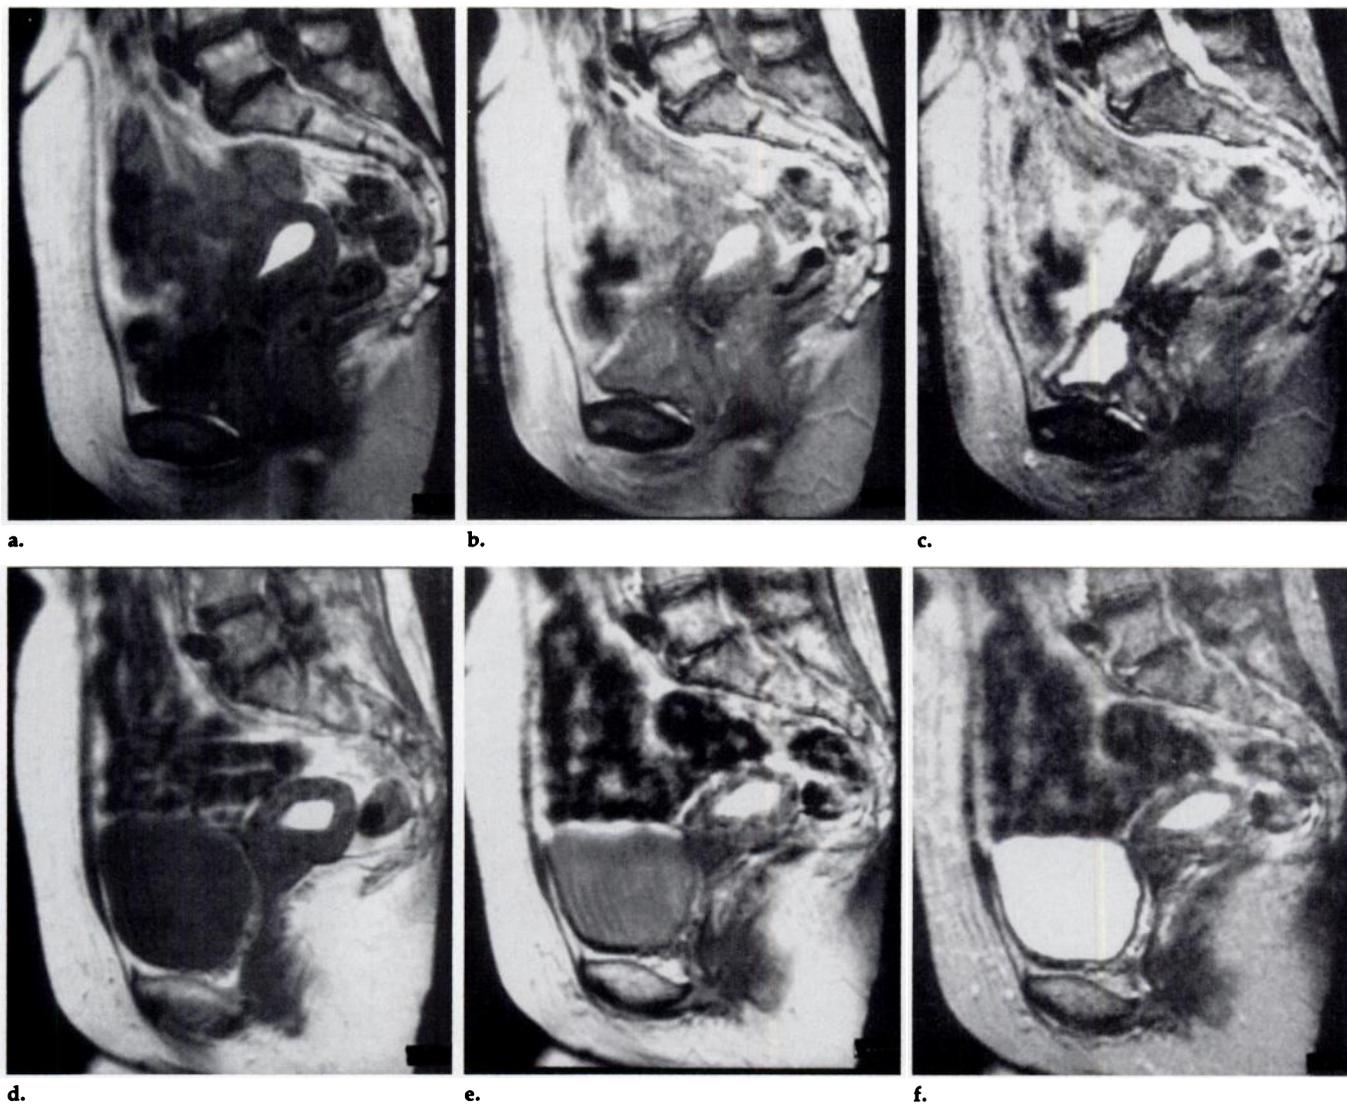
Precontrast (a–c) and postcontrast (d–f) images ([a, d] 450/20, [b, e] 2,100/29, [c, f] 2,100/100; 1.5 T) of a trial 2 patient with uterine cancer. Blood-filled uterus is shown; tumor is not visible on these images. Precontrast images fail to delineate parts of the anterior wall of the uterus and in part of the bladder because of feces-filled intestines. The delineation of the uterus is clearer on postcontrast images. Note excellent contrast enhancement on T1-weighted, T2-weighted, and intermediately weighted images.
